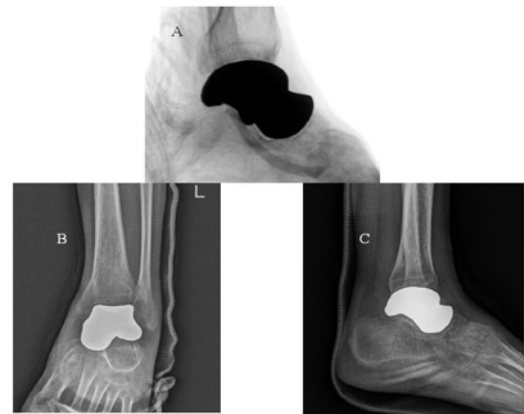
The fluoroscopy before closure demonstrated that the implant was perfectly fitted with the adjacent joints (A). Anteroposterior (B) and lateral (C) postoperative plain radiographs showed that the prosthesis was perfectly fitted with the adjacent joints.
